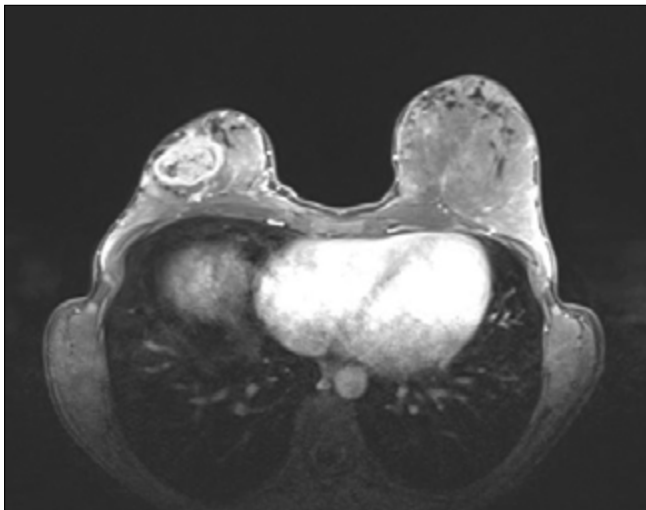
Magnetic resonance imaging view of breast mass in case 2.
